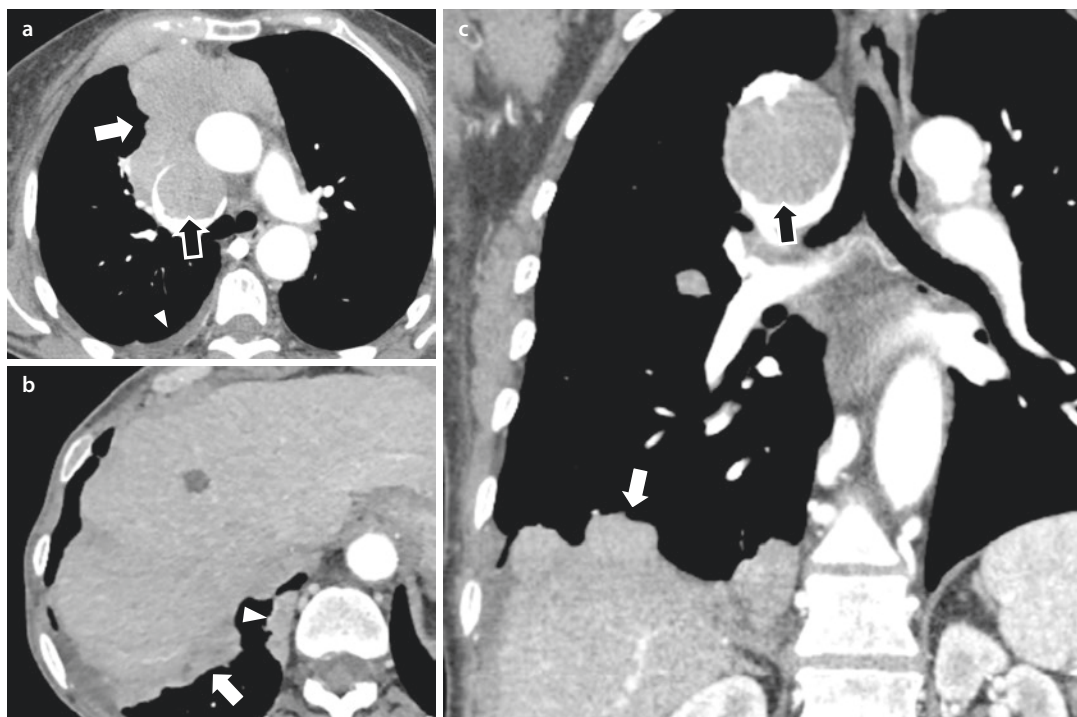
a Axial CT image after intravenous administration of iodinated contrast media showing a large, lobulated and homogeneously enhancing mass (white arrow) located in the prevascular compartment. The superior vena cava is enlarged, and a soft-tissue lesion grows into its lumen (black arrow). A small right pleural effusion can be detected (white arrowhead). b Same patient of a, at a caudal level. Pleural nodules
